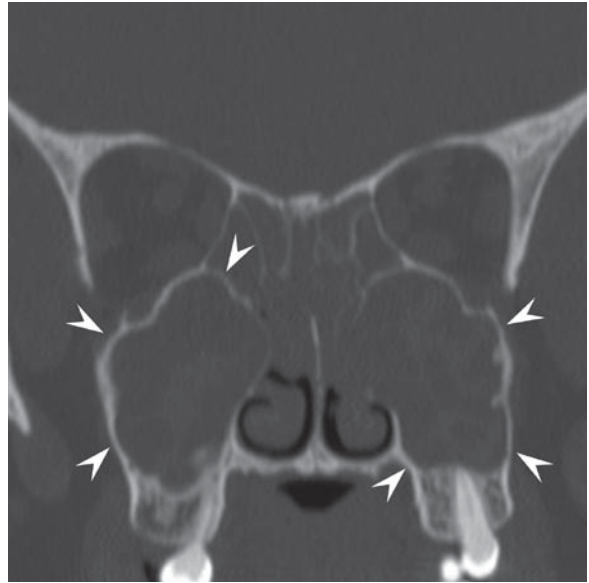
Bony remodeling from polyps. Coronal CT shows lobular remodeling of the maxillary sinus walls (*arrowheads*) in this patient with NP. This scalloped pattern suggests a benign etiology
